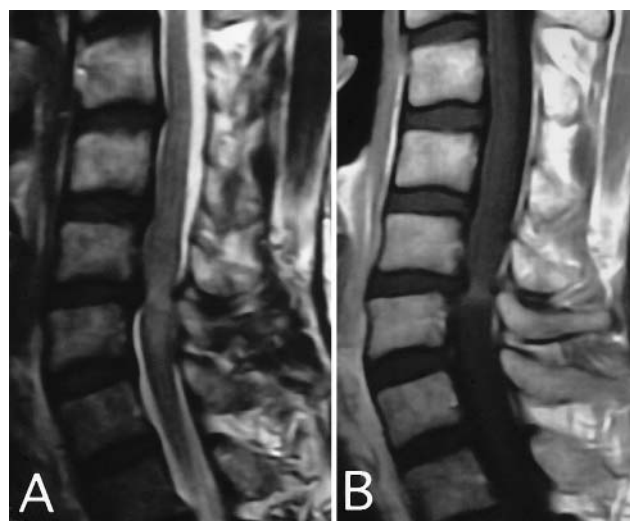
Case 2. Preoperative MR images. A: Sagittal T₂-weighted image revealing spinal cord compression at C5-6 level; intramedullary hyperintensity is also visible at the same level. B: Sagittal T₁-weighted Gd-enhanced image demonstrating the intramedullary enhancement at C5-6.
